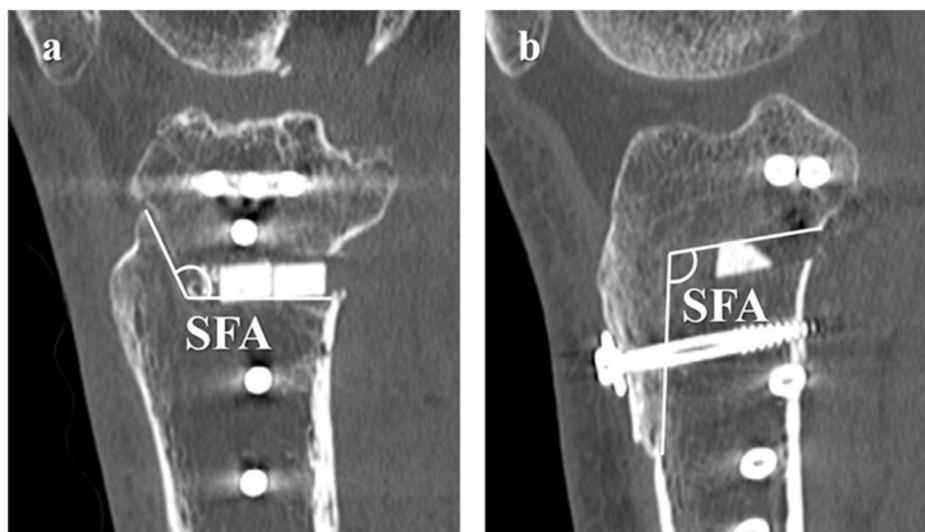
Measurement of sagittal flange angle (SFA) on sagittal CT slice in (a) high tibial osteotomy (HTO), and (b) distal tuberosity osteotomy (DTO) SFA was measured as the angle between the distal (HTO) or proximal (DTO) osteotomy plane and the flange osteotomy plane.
